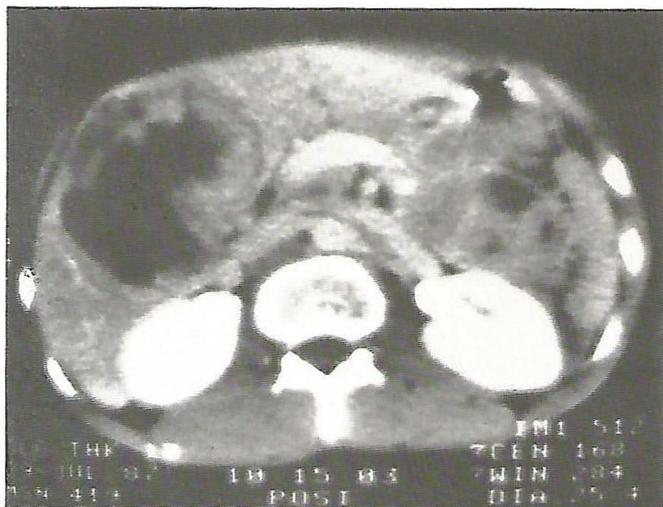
1. Pre-operative CT Scan of liver showing large tumour in right lobe
